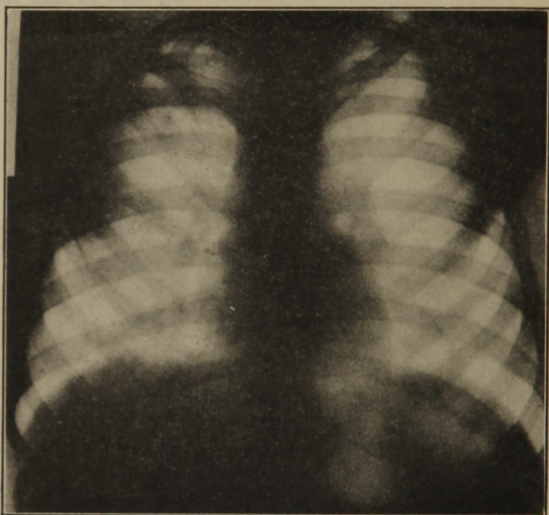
Radiograph of the same case as shown in Fig. 5, after repeated washings of the abscess. The shadow in the left lower lobe has disappeared, and expectoration of pus ceased.
